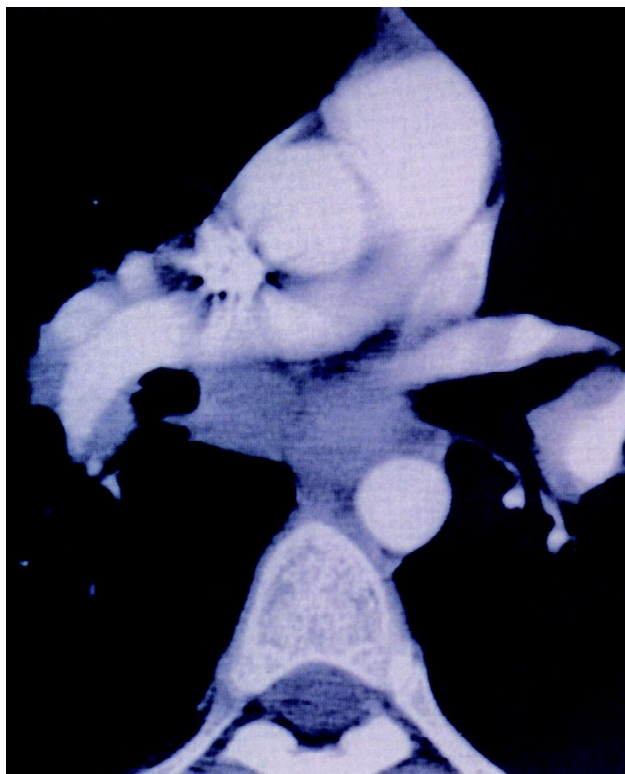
Contrast-enhanced CT scan (CECT) at a lower level of the same patient suggestive of bilateral hilar lymphadenopathy.
